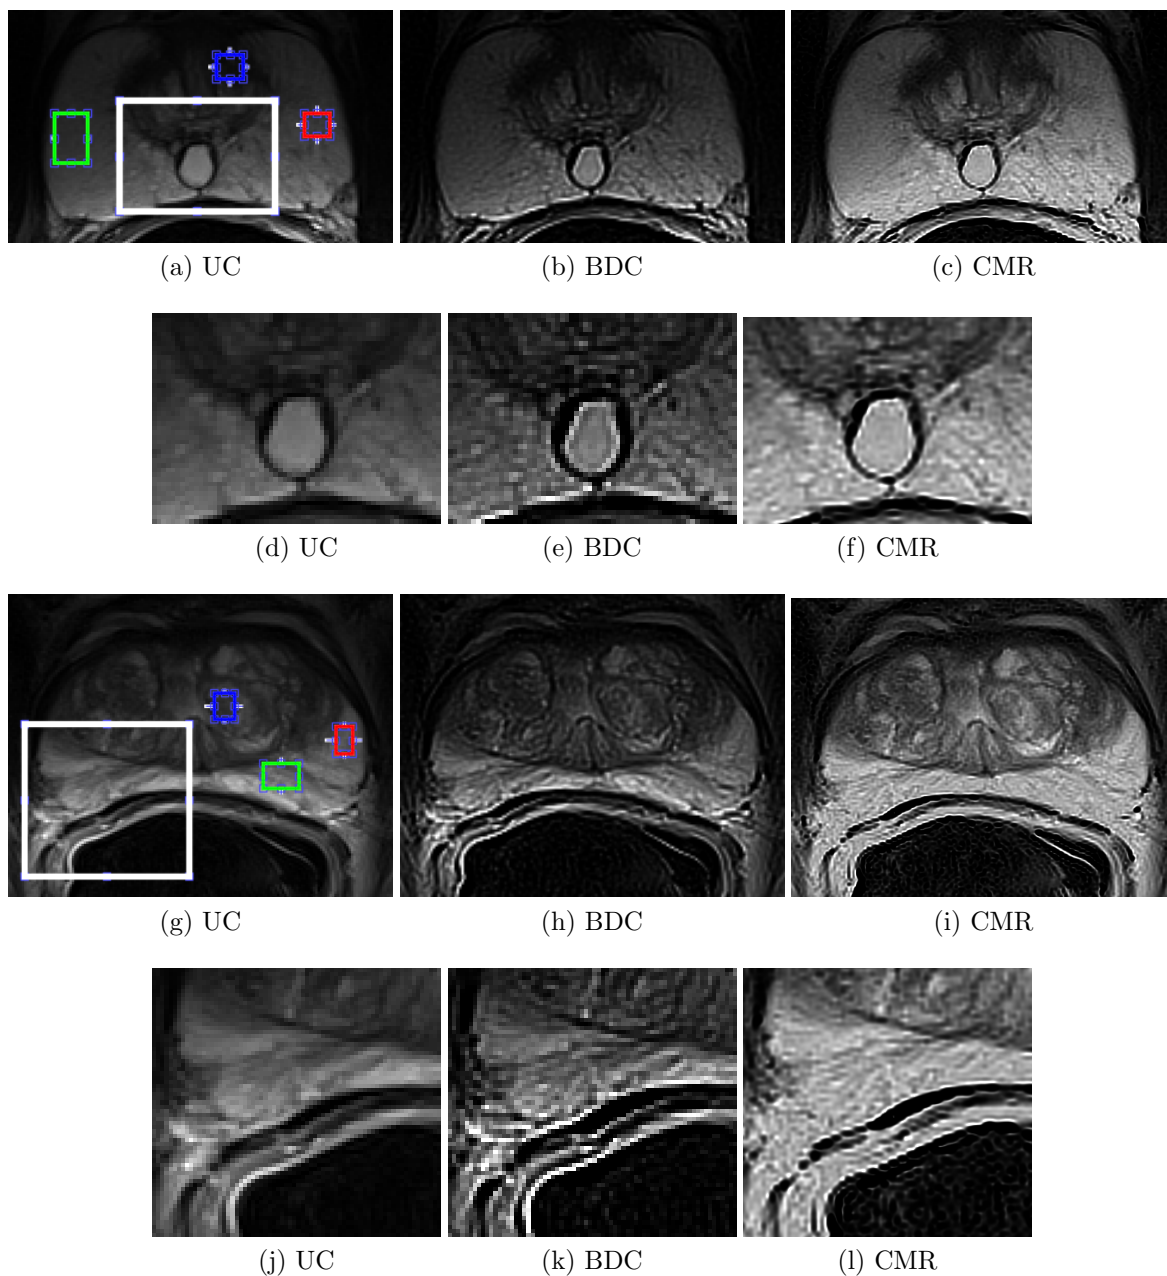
CMR imaging results using T2w-MR images. T2w-MR slices of prostate gland (a,g). Compensated T2w using (b,h) BDC method and (c,i) proposed CMR imaging. (d-f) and (j-l) are zoomed regions marked with white boxes on uncorrected (UC) T2w-MR images of (a) and (g).
